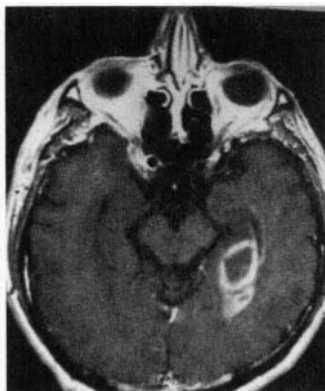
MRI of AIDS patient with toxoplasmosis. T1-weighted image obtained after the administration of intravenous contrast demonstrates numerous enhancing lesions throughout the brain.
